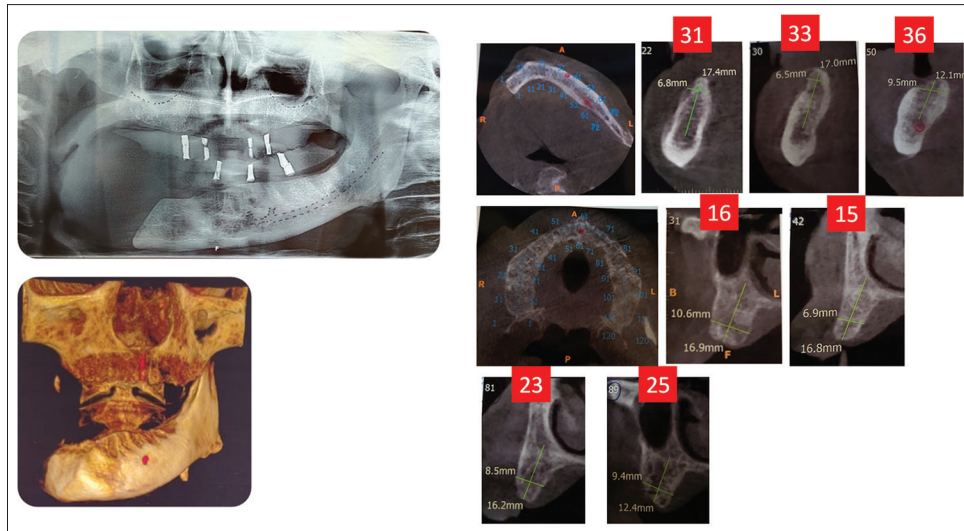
Orthopantomography and conebeam computerized tomography for bone mapping
